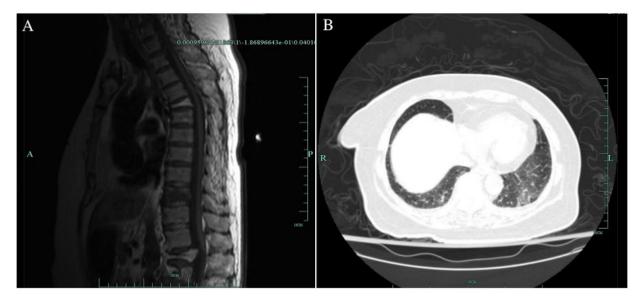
Patient scans. (A) Thoracic spinal MRI showed flattening of the 10th thoracic vertebra with abnormal signals suggesting subacute compression fractures, and wedge-shaped changes in the 5th thoracic vertebra and 1-3 lumbar vertebrae suggests old fractures. (B) Chest CT scan showed mild exudation in the basal segment of bilateral inferior lobes. MRI, magnetic resonance imaging; CT, computerized tomography.
